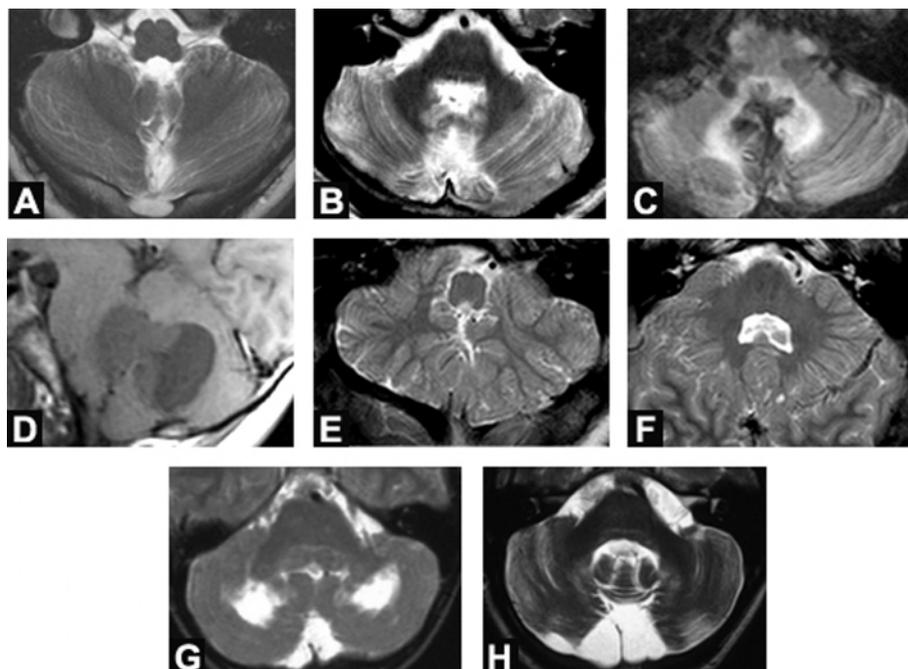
Magnetic resonance imaging (MRI) views of the cerebellum. (A) T2-weighted axial image in Case 1 following resection of a cerebellar vermis astrocytoma. (B) T2-weighted axial view in Case 2 following resection of a choroid plexus papilloma of the fourth ventricle. (C) Axial FLAIR view in Case 3 after resection of a juvenile pilocytic astrocytoma. (D) T1-weighted sagittal image of the cystic astrocytoma in case 6. (E) and (F) T2-weighted axial views of the cerebellar dysplasia in case 7 (E, inferior, F, superior). (G) and (H) T2-weighted axial views in Case 8, showing the evolution of the lesion at age 10 in (G) and age 19 in (H).
